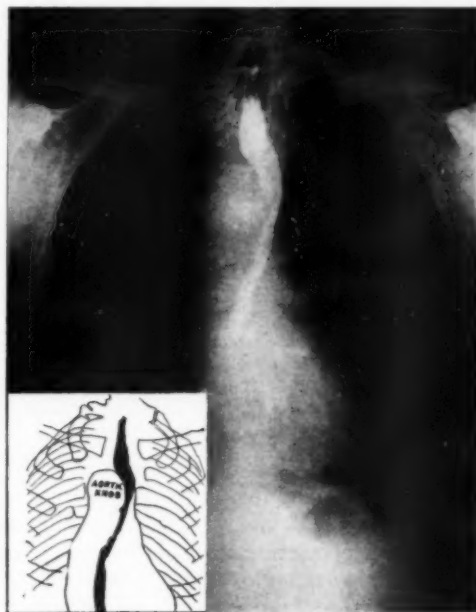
Posterior-anterior roentgenogram showing aortic knob to the right of spine and the esophagus displaced to the left.
